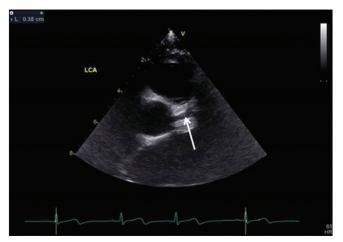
Parasternal short axis view of a 13 months girl is showing the perivascular brightness (arrow) of arterial wall and mild dilatation of the internal diameter as 0.38 cm of left main coronary artery on the 2nd day of high fever. LCA: left coronary artery
